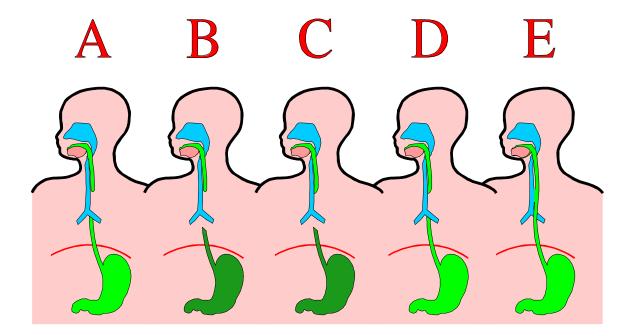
The type A, which is the most common, occurs in 85 to 93% of the cases. In a type A the proximal esophagus terminates into a blind pouch. However the distal esophagus is connected to the tracheobronchial tree, and therefore some fluid will pass into the stomach. Type B is the second most common, it occurs in 3-10% of the cases. Again the proximal esophagus terminates into a blind pouch but the distal esophagus is not connected to the tracheobronchial tree, and therefore no fluid will pass into the stomach and the stomach will appear too small. In type C there is a connection of the distal part of the proximal portion of the esophagus, but again, no connection of the distal portion, and therefore again, no fluid will pass into the stomach and the stomach and the stomach will not be full. In type D that occurs in 1-1.5% of the cases, both the proximal and the distal portion of the esophagus are connected to the tracheobronchial tree and therefore the ultrasound appearance of the stomach will be essentially normal. And finally in type E that occurs in 1.8 to 4% of the cases the esophagus is continuous, but has an H connection to the tracheobronchial tree, and therefore the stomach will also appear normally full.
